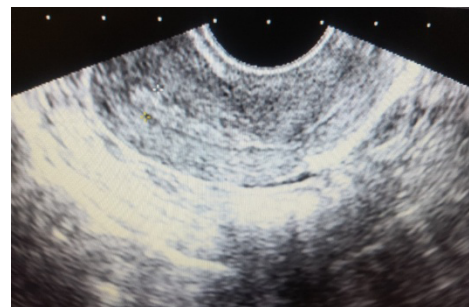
Postoperative transvaginal ultrasound showed a smooth and regular endometrial lining
